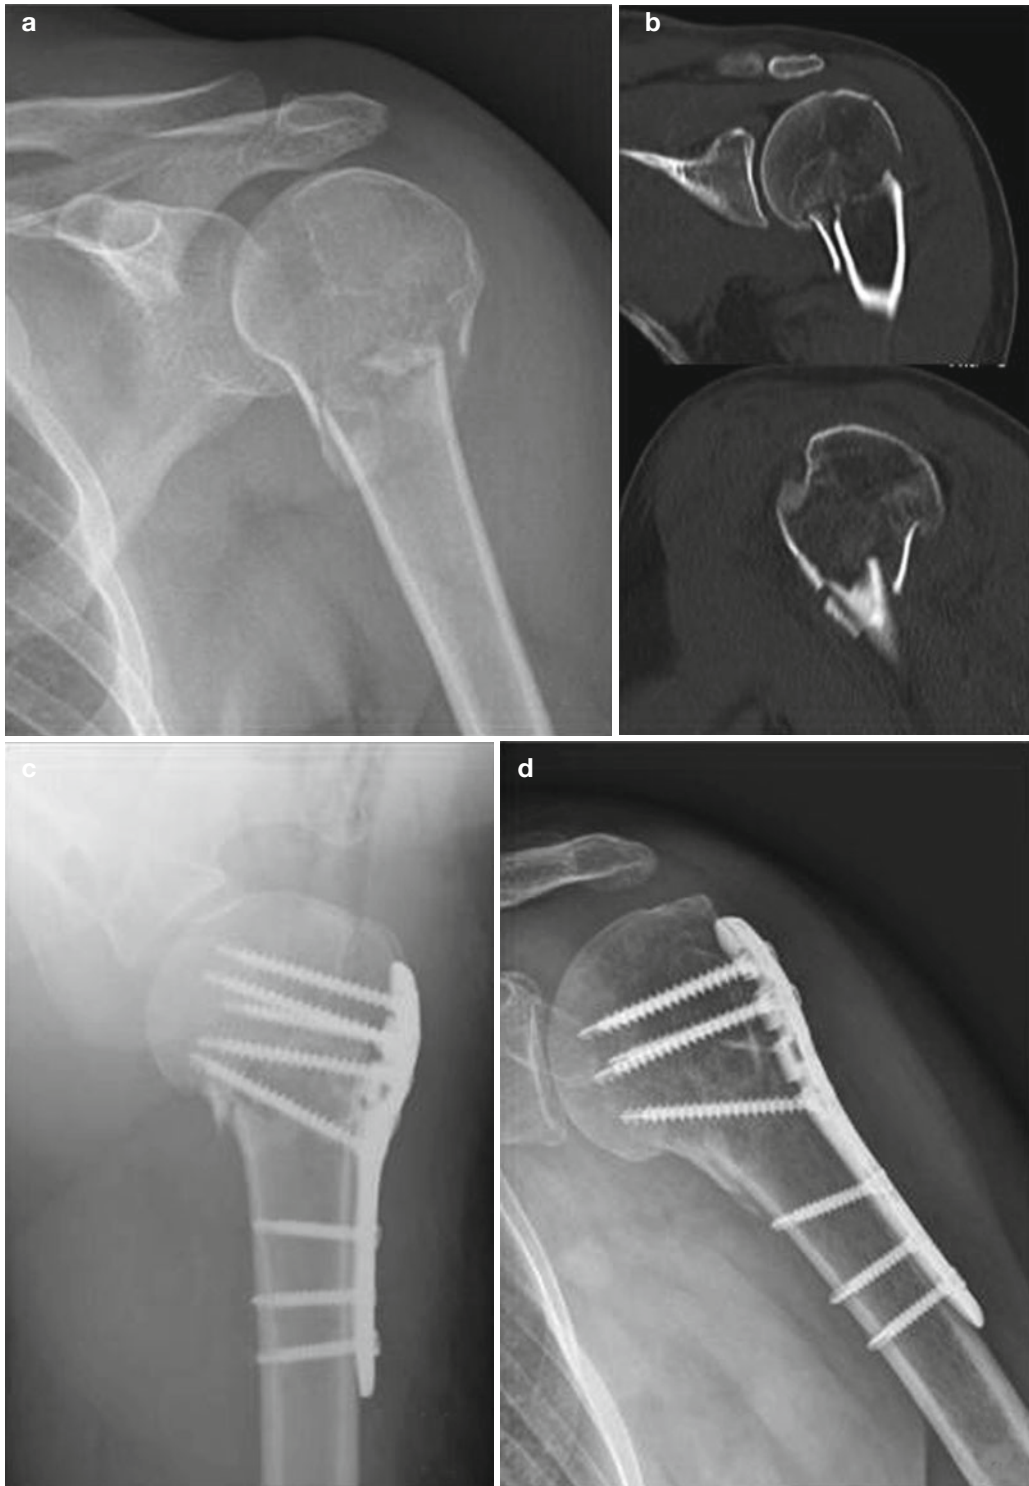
Surgical neck fracture in a 50-year-old woman. (a, b) Preoperative radiograph and CT scans showing an inferomedial fragment detachment causing a calcar defect.
